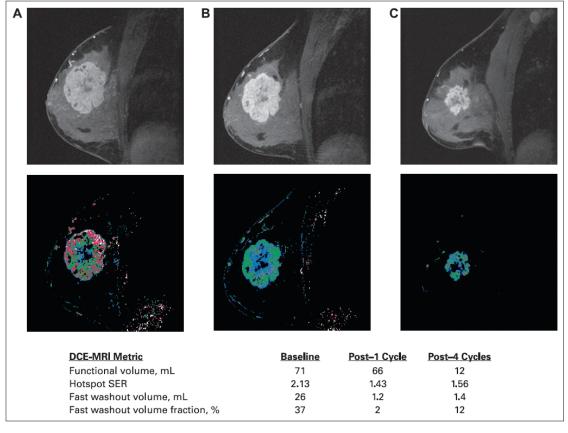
Contrast-enhanced magnetic resonance images (top row) and signal enhancement ratio (SER) parametric maps (bottom row), acquired before treatment (A), 2 weeks after the first cycle of doxorubicin-cyclophosphamide (B), and at the end of chemotherapy, before surgery (C), for a patient with locally advanced breast cancer. Blue, green, and red color coding corresponds to low, moderate, and high values, respectively. [13]
